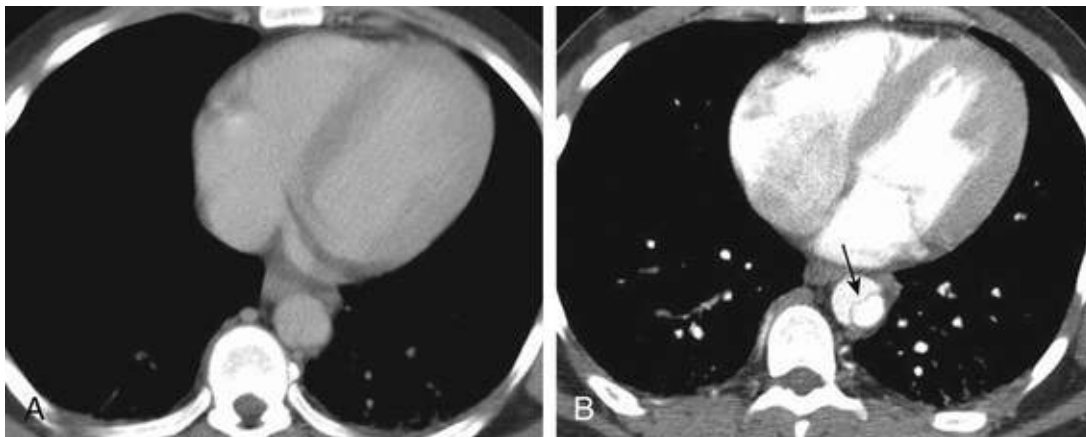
Importance of contrast-enhanced computed tomography (CECT) in aortic dissection. CT scan of type B aortic dissection. A, Non-CECT fails to identify the dissection or intimal flap. B, CECT identifies the intimal flap (*arrow*).
